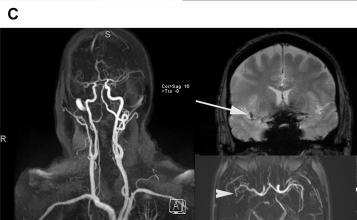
A 71-year-old woman with past medical history of hypertension and coronary artery disease with cardiomyopathy presented with sudden onset of left-sided facial, upper extremity, and lower extremity weakness. Baseline NIHSS: 4. Time from onset to imaging: 110 minutes. Sequentially aligned DWI, ADC, FLAIR, DSC-T<sub>max</sub>, CBF, and CBV (A) and a coronal and axial maximum intensity projection from CE-MRA in addition to coronal GRE image (B) are shown. There is an acute infarction involving the right opercular region (arrowhead on DWI). Note that there is no corresponding FLAIR hyperintensity, which indicates the hyperacute nature of the infarction (time from onset to imaging was 110 minutes). On perfusion images (B), the  $T_{max}$ lesion (delayed perfusion) (white arrows) and CBF lesion (hypoperfusion) (red arrows) are both larger than acute infarcted tissue seen on DWI (arrowhead in A), a representation of ischemic penumbra (so diffusion-perfusion mismatch). The CBV lesion (white arrowhead) is significantly smaller, closely mimicking the infarction core, as expected. CE-MRA (C) shows normal appearance of the cervical arteries. There is occlusion of the right M2 posterior division (arrowhead). GRE (C) shows increased blooming, indicating a thrombus (arrow).
